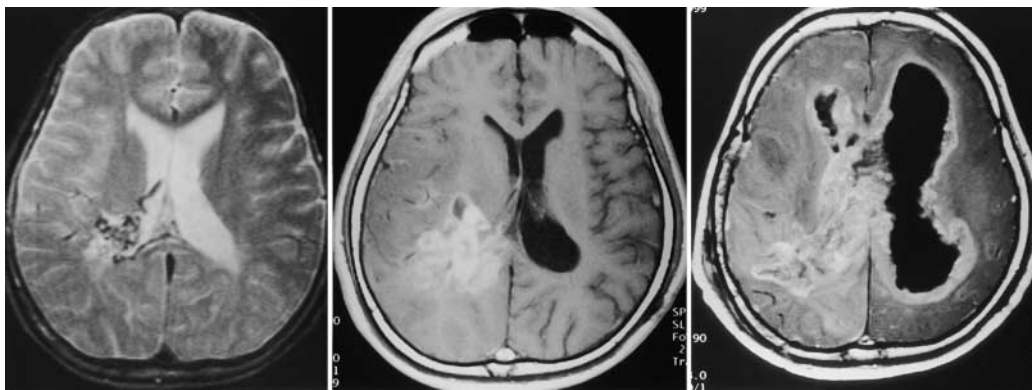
Axial T₂-weighted (*left*) and gadolinium-enhanced T₁-weighted (*center and right*) MR images. *Left*: Preradiosurgery MR image revealing an AVM in the right parietal lobe. *Center*: An MR image obtained 81 months after radiosurgery, demonstrating an enhanced mass lesion in the right parietal lobe. *Right*: An MR image obtained 99 months after radiosurgery (9 months after removal of the tumor) and 6 days before the death of the patient, demonstrating severe invasion and dissemination of tumor.
